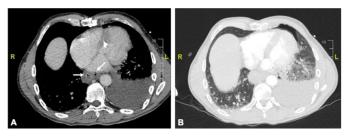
(A) Chest computed tomography scan with injection of iodinated contract: distal esophagus rupture with pneumomediastinum facing the left ventricle. (B) Chest computed tomography scan in pulmonary window: large left pleural effusion with small ipsilateral pneumothorax.
